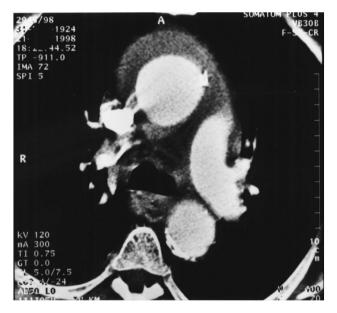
CT scan showing the large intramural hematoma of the ascending aorta.
